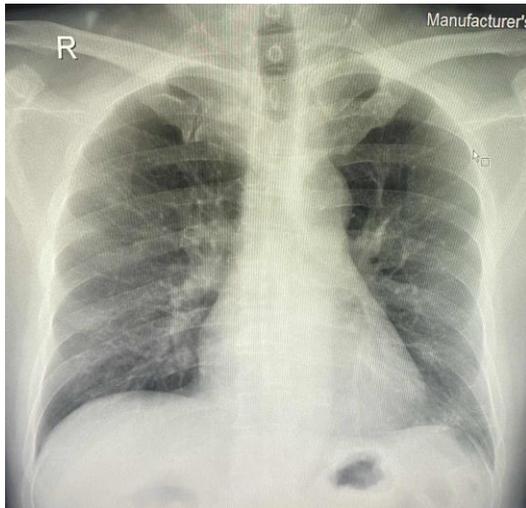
Hospital Day 1 – initial chest xray showed hazy opacities in both lower lungs
